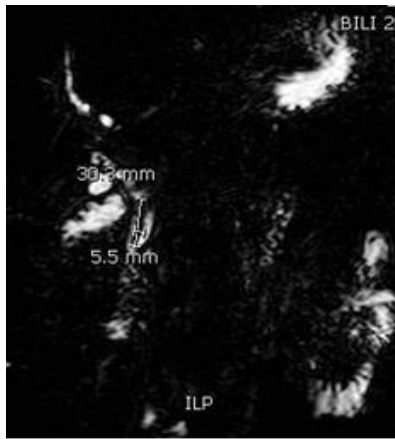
Biliary MRI with an oblong-shaped lithiasis
